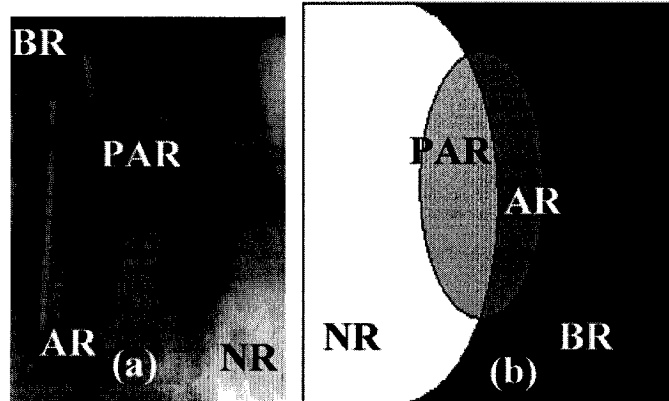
Pathological modelling of dental X-ray. The dental X-ray image can be divided into four regions:  $\Omega_{NR}$ ,  $\Omega_{PAR}$ ,  $\Omega_{AR}$ , and  $\Omega_{BR}$ .
